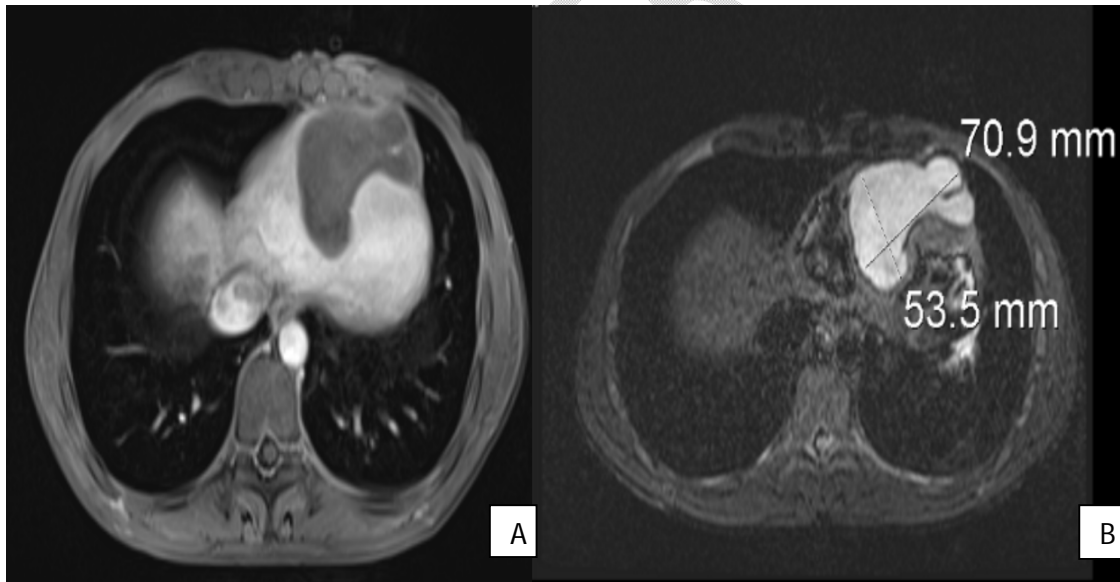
MRI showing a well-circumscribed polylobed pericardial cystic mass with liquid signal in T1 hyposignal (A) and hyper signal T2(B), segmented with discrete contrast of the wall and the septum.
